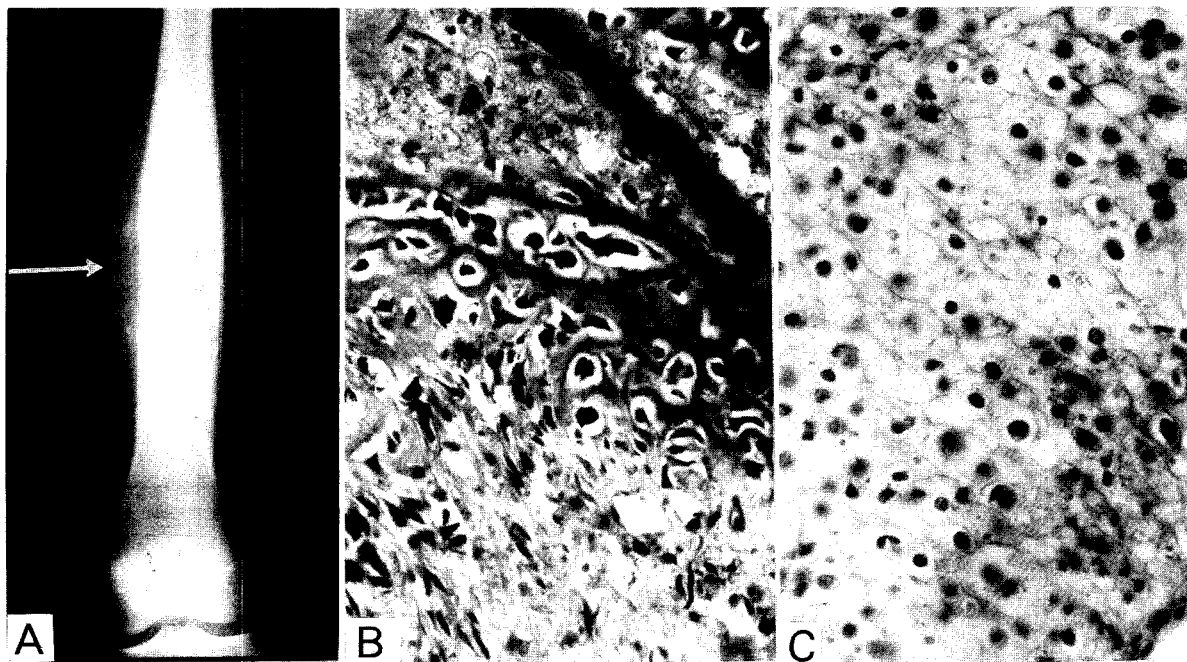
Case 2. A: Plain radiograph at the first visit showing periosteal reaction of the diaphysis of the left femur (arrow). B: Typical osteoblasts with osteoid formation (H. E., $\times 200$). C: Chondroid substance (H. E., $\times 200$).
